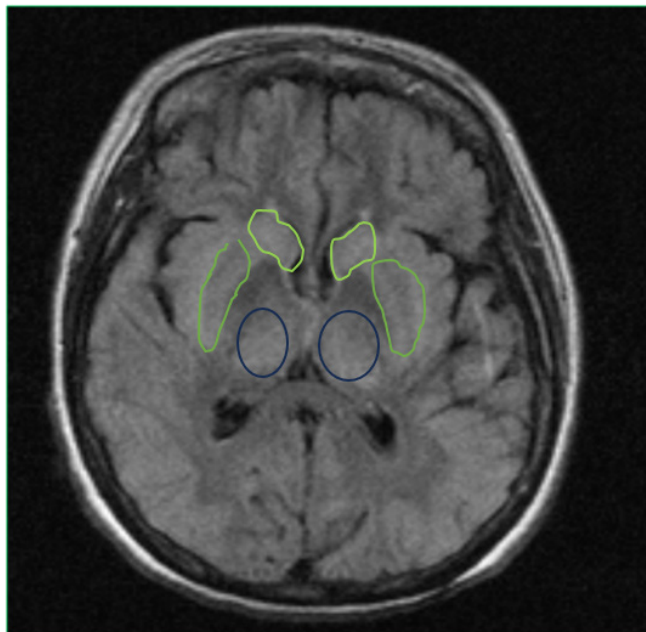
MRI scan of the brain of our patient showing signal abnormalities and diffusion restriction in the basal ganglia in keeping with osmotic demyelination syndrome; Thalami: Caudate nuclei; Putamina.
